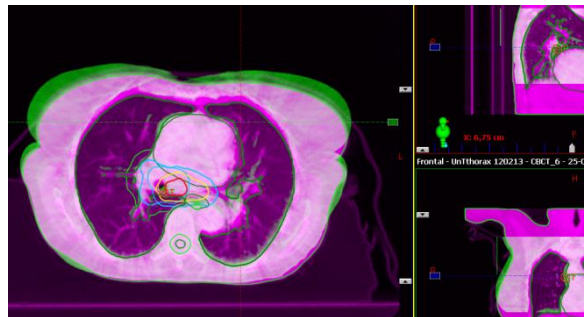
The bone registration of the CBCT at fraction 6 on the initial CT for patient 24 revealed significant anatomical change as a result of bloated breasts.
